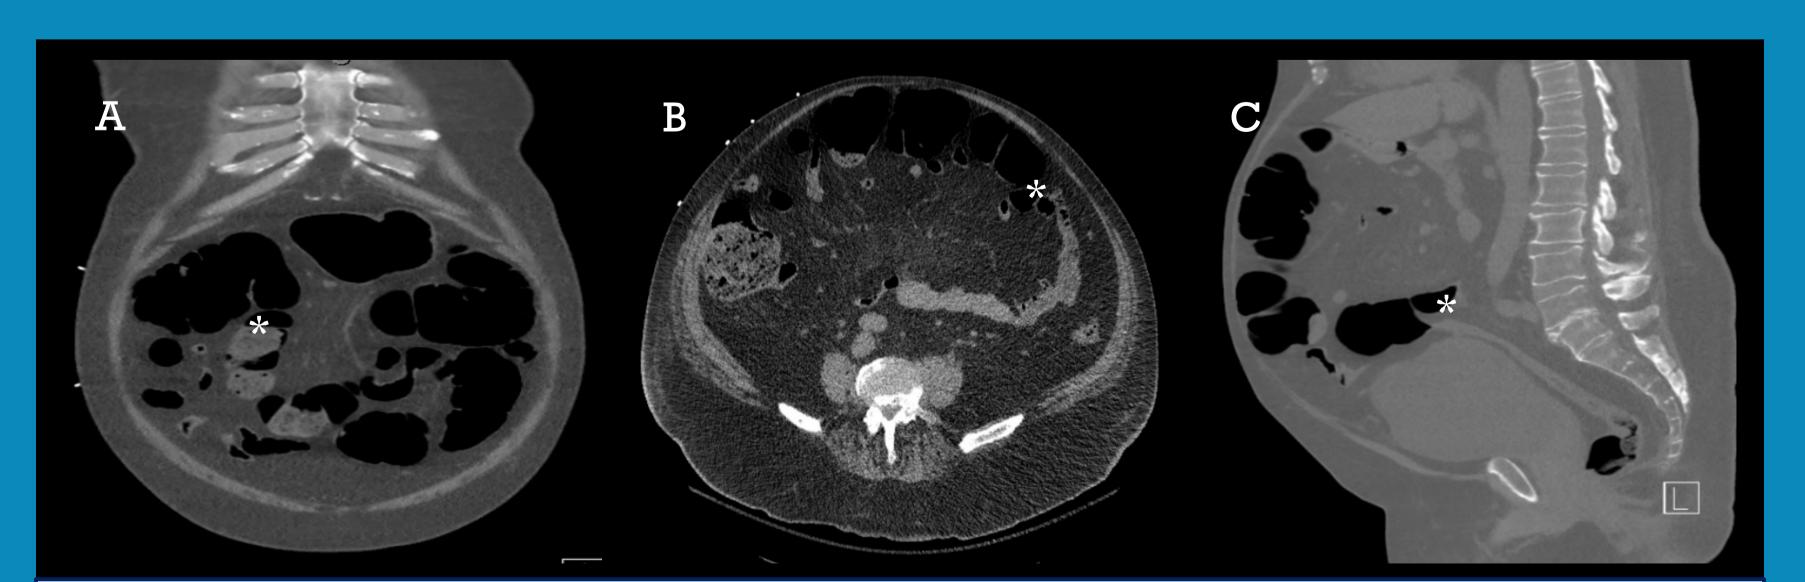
CT abdomen and pelvis with contrast A. (coronal view) Extensive colonic distention with fecal impaction B. (axial view) Moderate colonic distention seen with transition point in the distal sigmoid colon with increased stool burden C. (sagittal view) Moderate colonic distention seen with transition point (*) in the distal sigmoid colon with increased stool burden.
